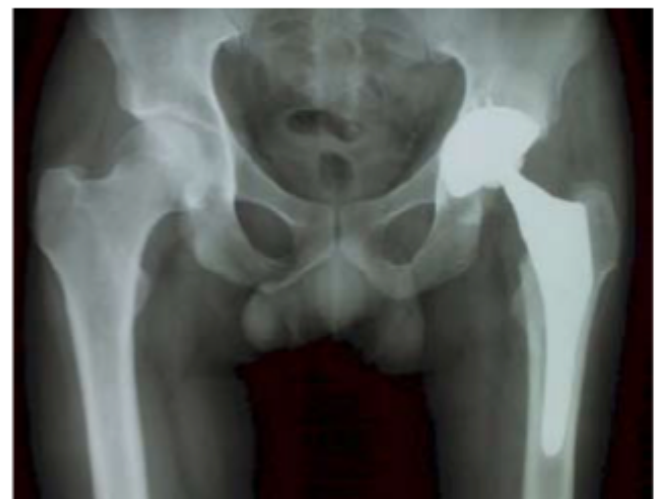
Hip X-ray in anterior-posterior projection, showing the excellent result on follow up at 14 years.
